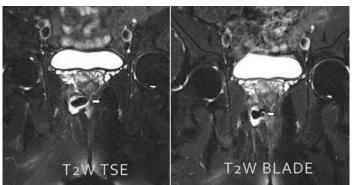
Coronal plane of fat-suppressed T2-weighted (T2W) BLADE sequence and T2W TSE images obtained from a 42-year-old man suffering from pain and discharge in the perianal region.
